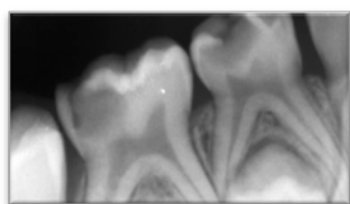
Preoperative intra oral periapical radiograph showing extensive carious lesions in mandibular primary molars, with more than two thirds of root length, and absence of furcal/ periapical radiolucency
